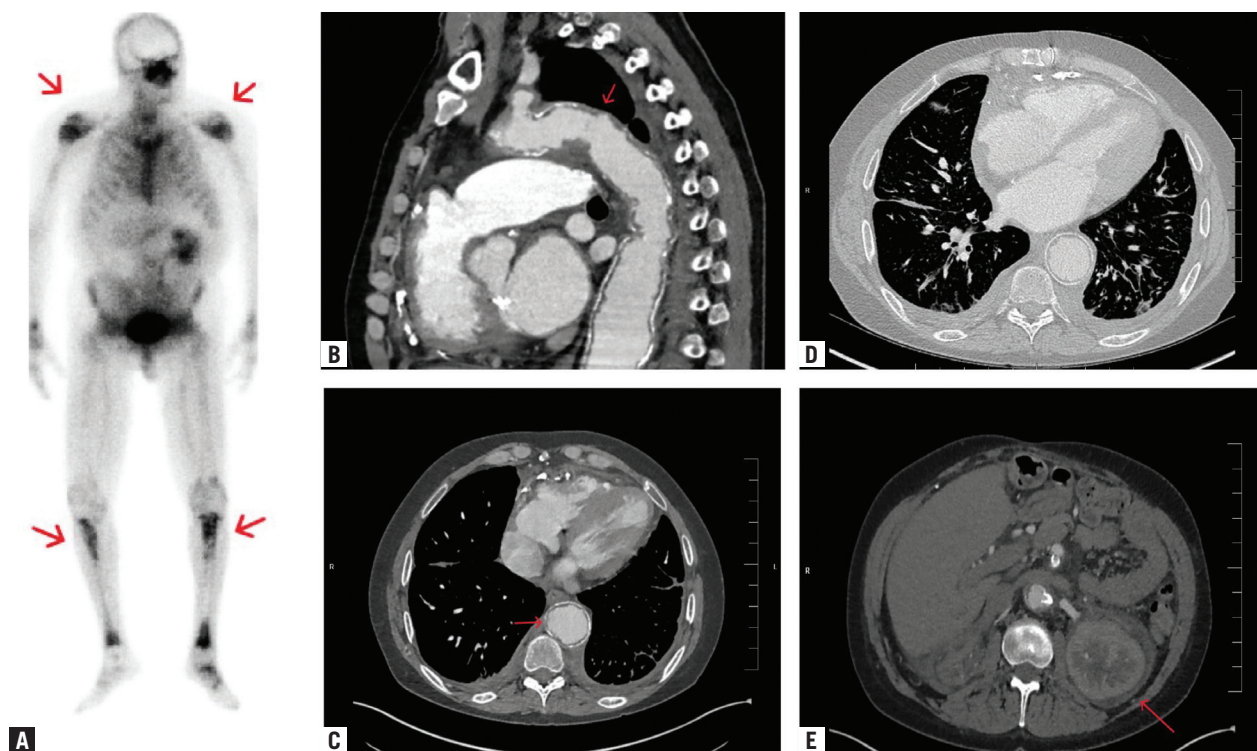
CT Scan of Patient With ECD
